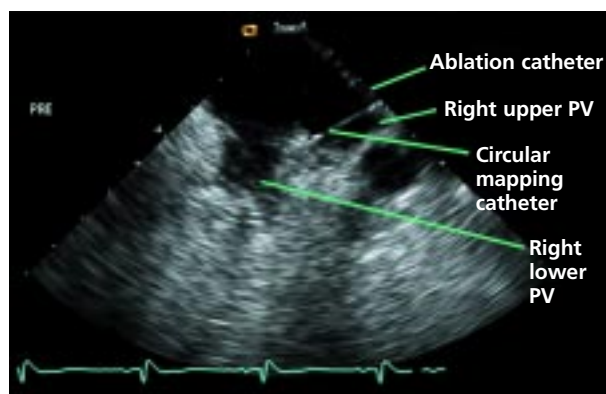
A phased-array intracardiac echocardiogram used to guide pulmonary vein (PV) isolation. Here the right upper and right lower PVs are visible. The circular mapping catheter is placed at the ostium of the right upper PV.
